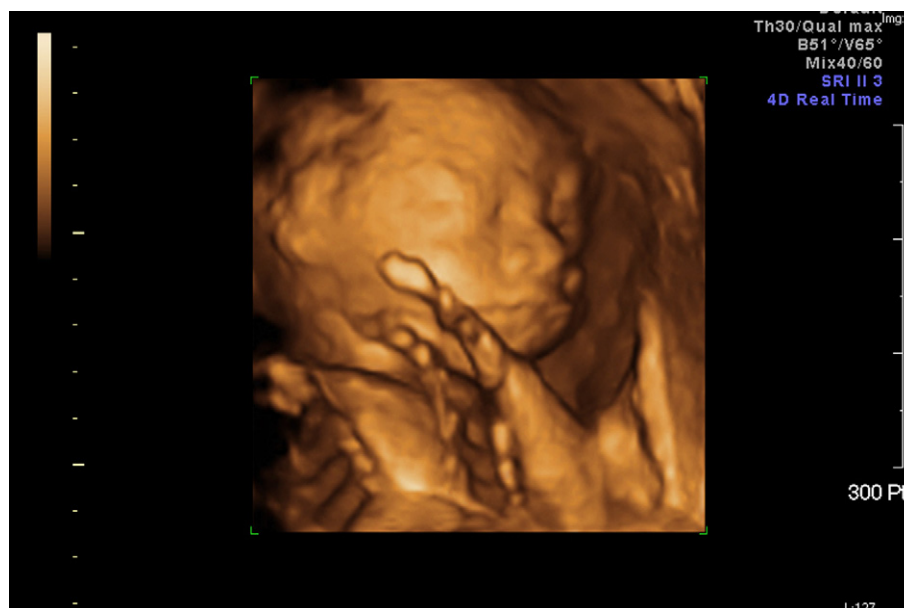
Prenatal 3-D ultrasound (surface render mode) of CCAML type III at 21 weeks of gestation (the same case as in Fig. 1).
